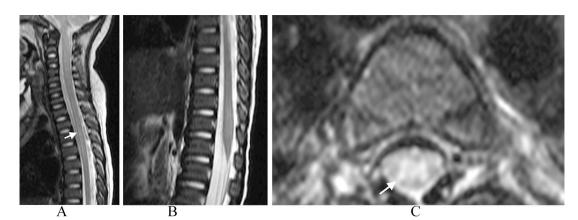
Sagittal (A,B) and axial (C) T2 weighted spine MRI images, showing; (A) Long segment abnormal high signal intensity noted from the level of T2 to T5 vertebra (arrow), with no obvious cord expansion. (B) Abnormal high signal intensity is seen involving the conus medullaris, with cord expansion. (C) The abnormal high signal intensity is noted to be confined centrally (in the gray matter), with sparing of the periphery ("H" sign). This is at the level of T5 vertebra.
